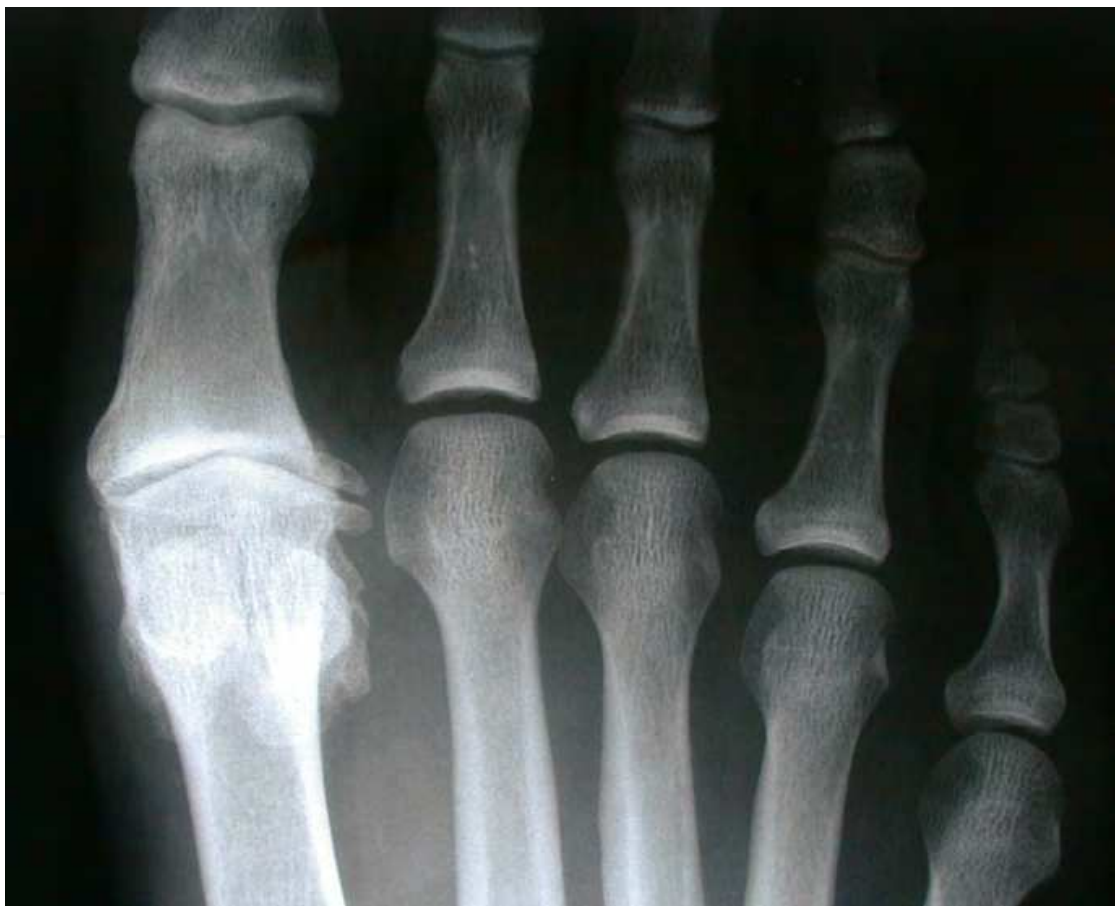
Late Stage III Hallux Rigidus. Pre-operative AP radiograph with clear evidence of joint narrowing and osteophytic formation.
